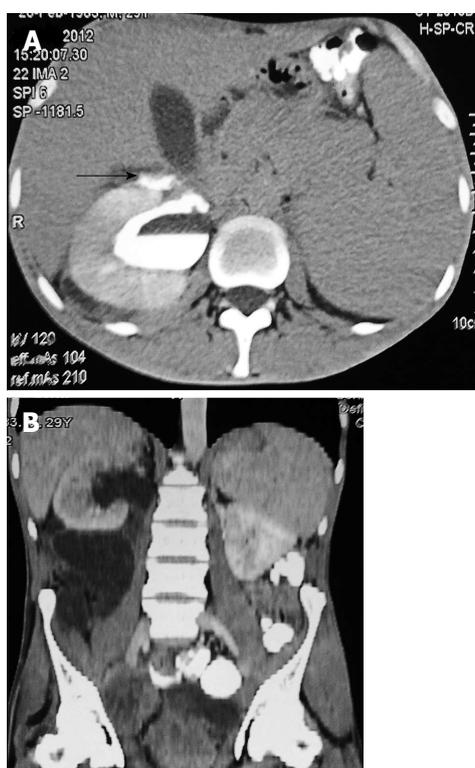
Computed tomography imaging. A: Axial contrast enhanced computed tomography (CT) of the abdomen shows a leak of contrast from the hydronephrotic right renal pelvis into the perinephric space (black arrow); B: CT coronal reconstruction shows a large retroperitoneal urinoma below the right kidney.
